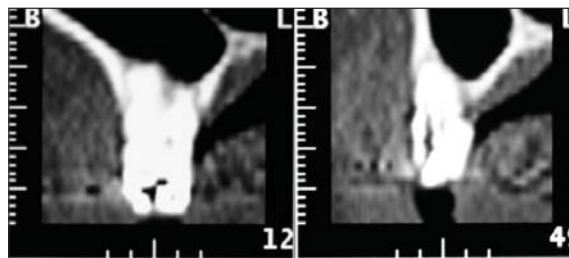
CT scan cuts of right and left first molar areas showing insufficient bone volume to house implants.
